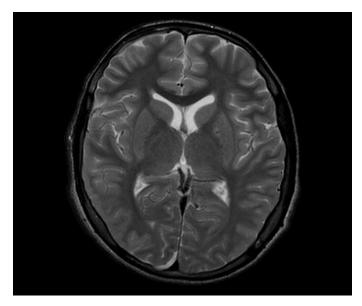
MRI brain showing T2W hypo intense areas involving bilateral head of caudate and lent form nuclei
